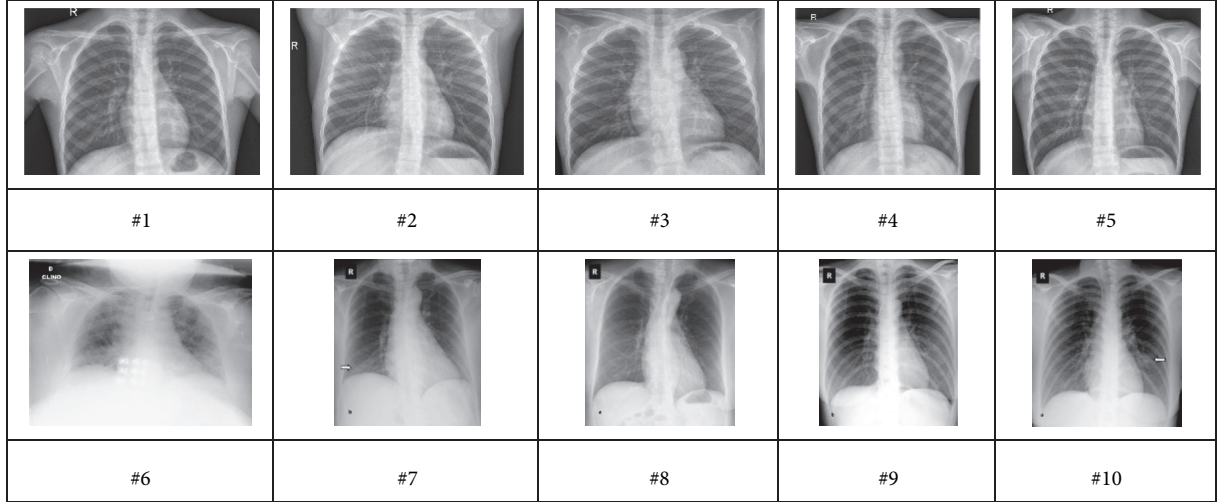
Some examples of COVID-19 chest X-ray images.
